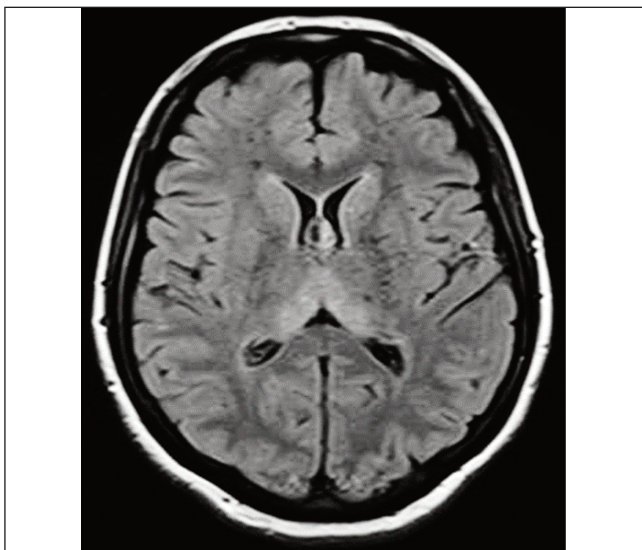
FLAIR sequence showing high signal abnormality in bilateral medial thalami.
